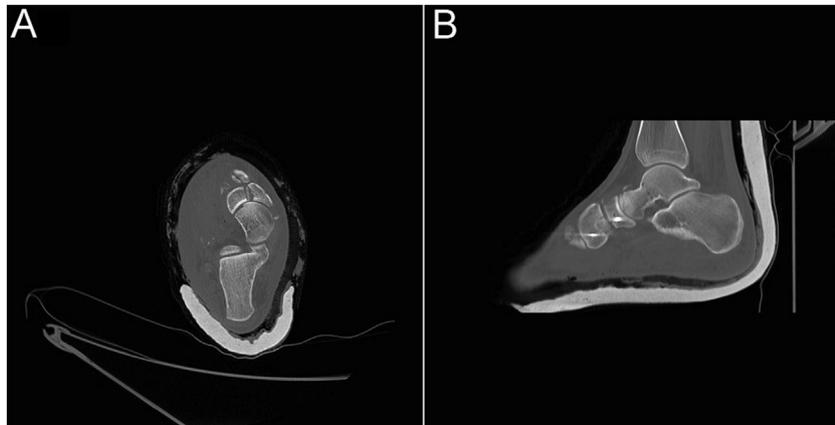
Pre-operative CT images demonstrating impaction of the head of the talus in a high-energy injury requiring temporizing external fixation (Type E). In these cases, it may be necessary to bridge onto the neck of the talus.
